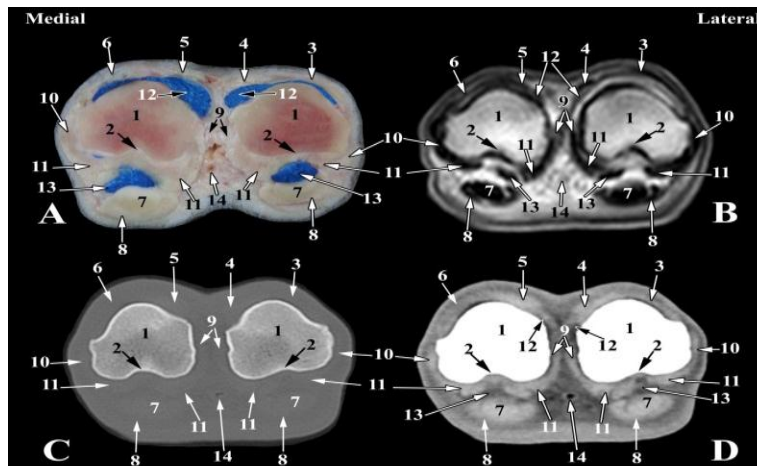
Transverse images of left hind fetlock joint of camel at the level of proximal phalanges (Level 3 as indicated in Fig. 1). A- Transverse anatomical section; B- Magnetic resonance image; C- Bone window computed tomography image; D- Soft tissue window computed tomography image: 1- Proximal phalanx; 2- Trochlear fovea of proximal phalanx; 3- Lateral digital extensor tendon; 4- Lateral branch of lateral limb of common digital extensor tendon; 5- Medial branch of lateral limb of common digital extensor tendon; 6- Medial limb of common digital extensor tendon; 7- Deep digital flexor tendon; 8- Superficial digital flexor tendon; 9- Axial collateral ligaments; 10- Abaxial collateral ligaments; 11- Straight sesamoidean ligaments; 12- Dorsal synovial pouch of fetlock joint; 13- plantar synovial pouch of fetlock joint; 14- Common plantar digital artery.
